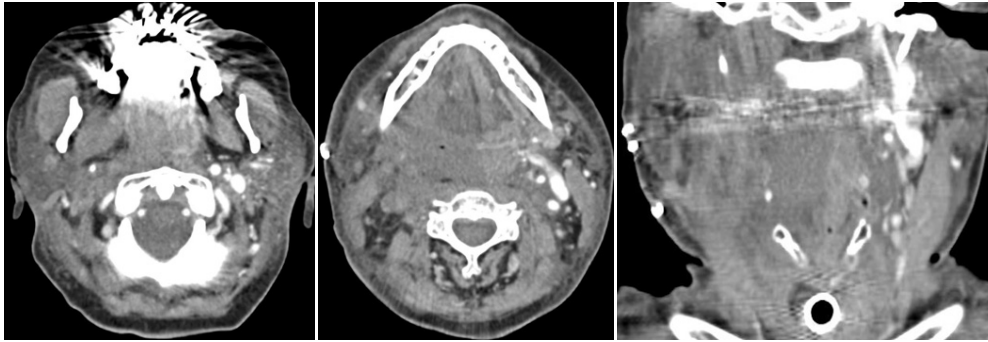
Computed tomography scan. Day + 14 after transplantation
